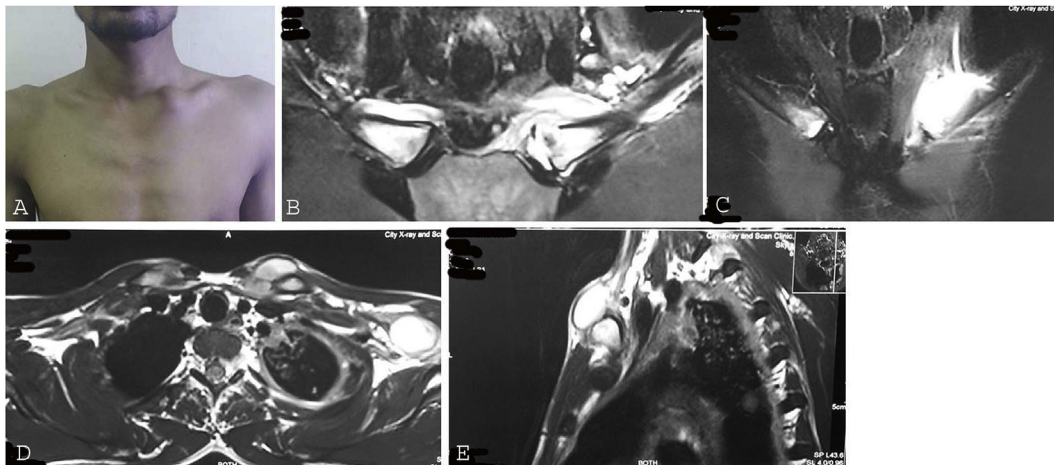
A: Clinical picture showing healed scar. 1B: Chest radiograph with lucency in medial end of clavicle on right side. 1C: Axial section of MRI showing abscess. 1D: Sagittal section of MRI showing collection at medial end of clavicle. 1E: Coronal MRI section showing abscess.
